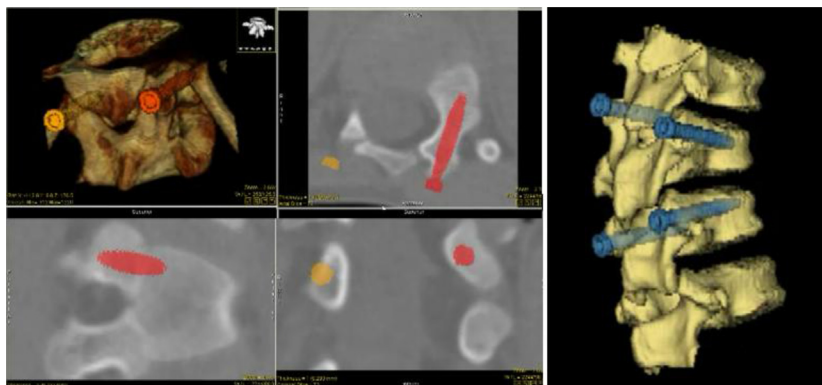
Snapshot of the spine surgery platform interface showing the interactive templating of the subject-specific computed tomography spine dataset visualized in the axial, coronal, and sagittal planes, accompanied by the resulting virtual model of the subject-specific instrumented spine segment.
